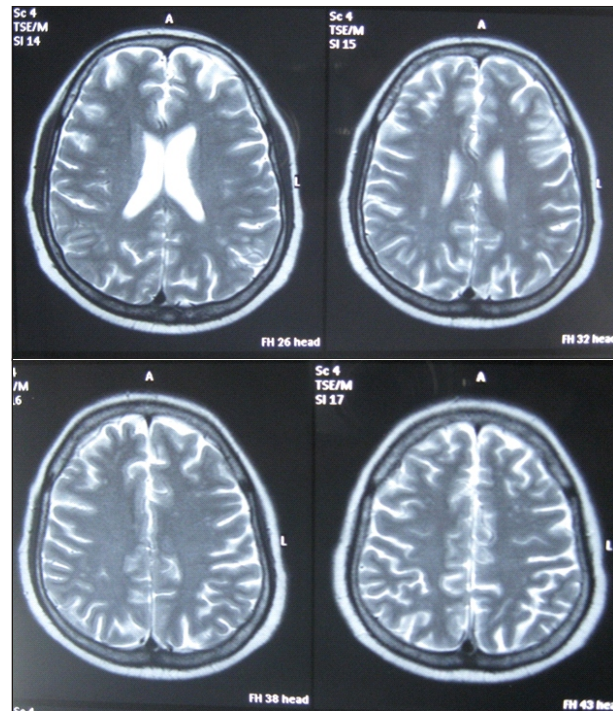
MRI imaging of brain of patient showing ill-defined T2 hyperintense areas in subcortical white matter in bilateral fronto-parietal & occipital region
